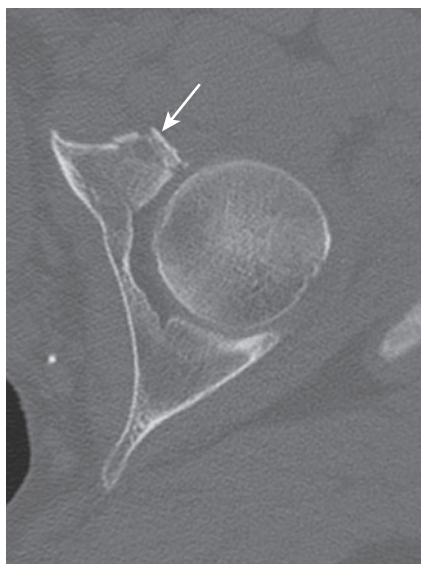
Axial computed tomography of the left hip demonstrating a comminuted minimally displaced fracture of the anterior aspect of the acetabulum (arrow), which was not appreciable on plain radiographs.
